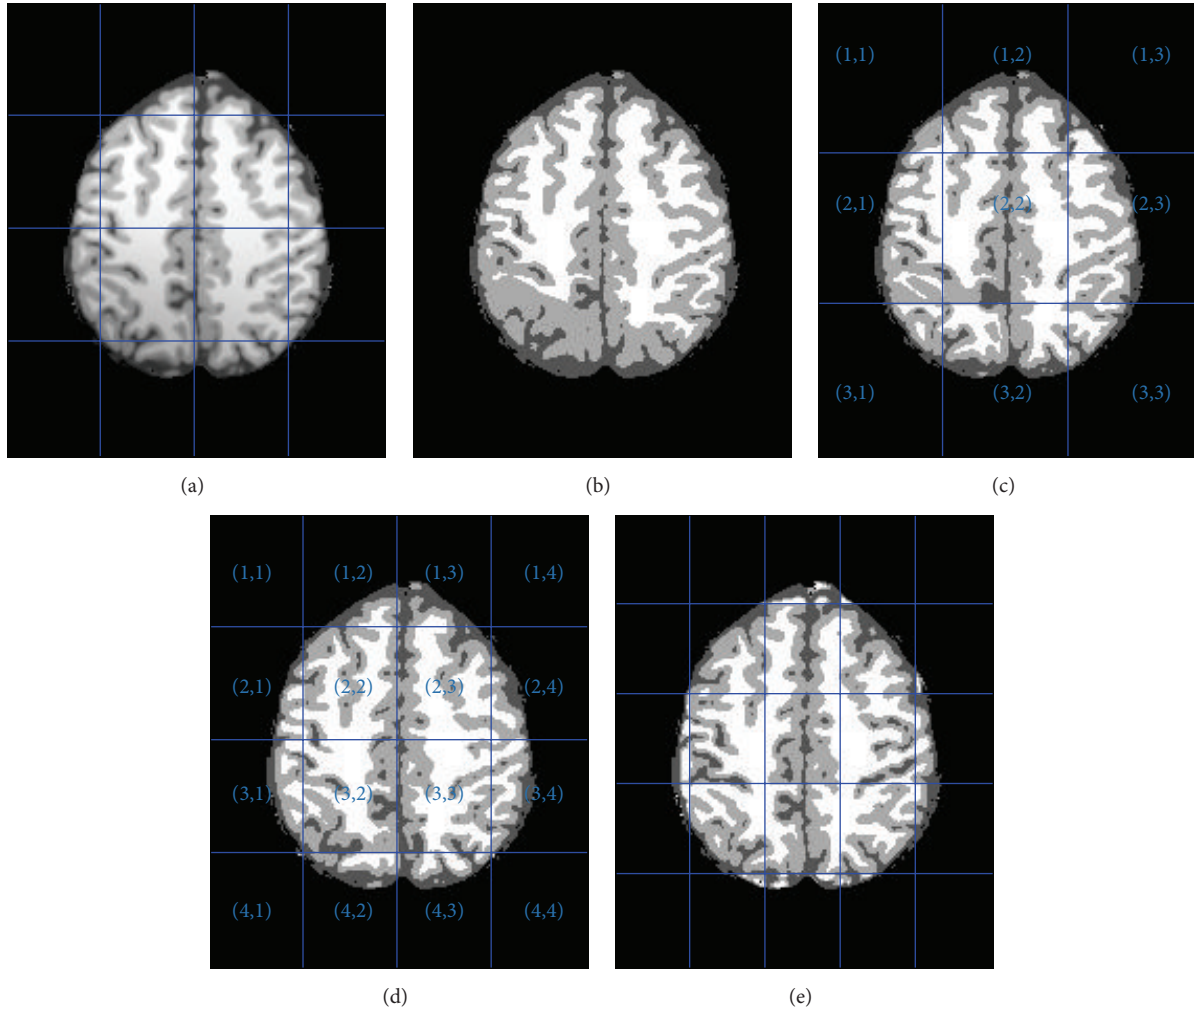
Brain image segmentation: (a) original T1-weighted image; (b) GMM segmentation; (c)–(e) MGMM segmentation.
